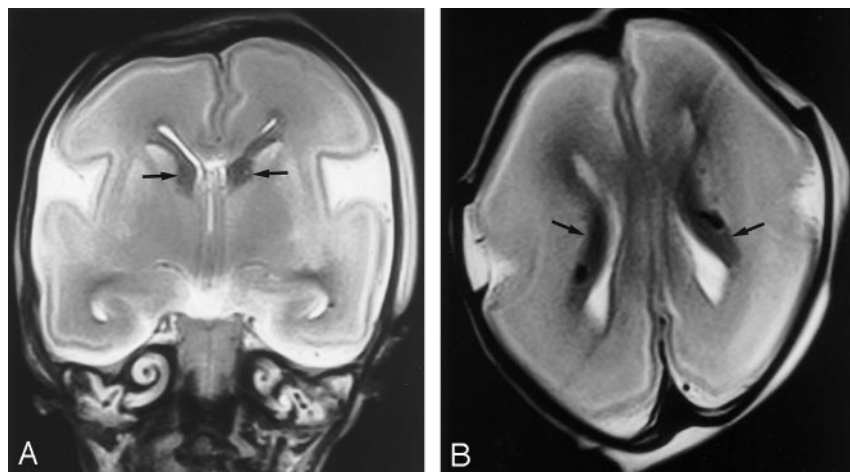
A, Coronal and B, axial brain MR images in a spontaneously aborted 22-week fetus. The image quality was assessed as excellent and findings reported as normal, which agreed with the autopsy report. The dark structures (arrows) in the immediate periventricular regions are the germinal matrices. Migrating neurons are shown in cerebral hemispheres as gray matter signal intensity against the high signal intensity of the white matter.
